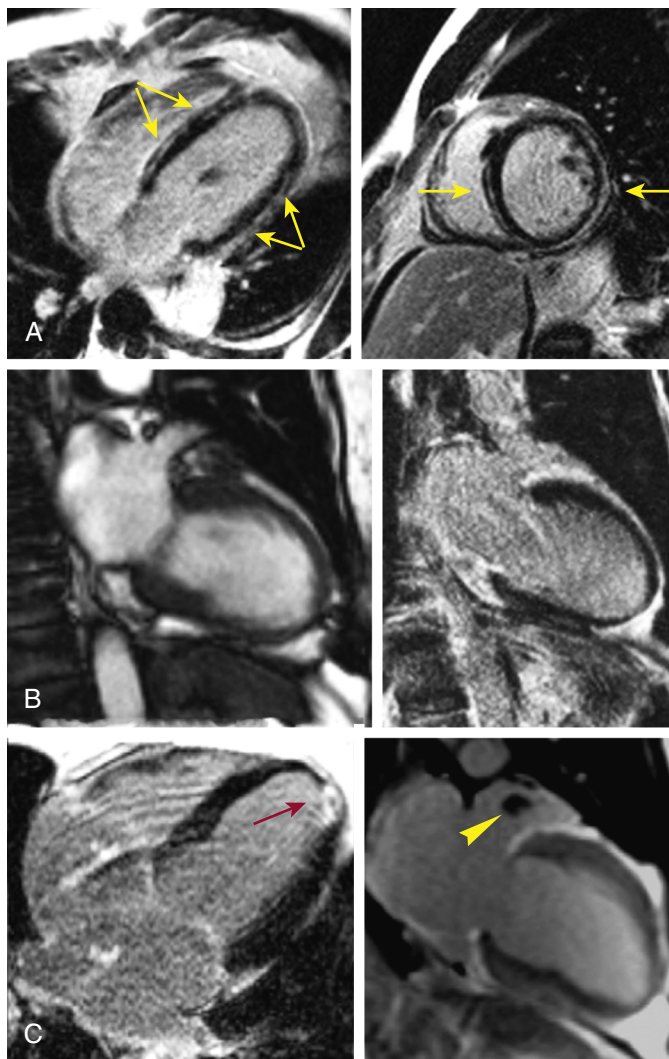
e12 Typical delayed-enhancement cardiac magnetic resonance images from three patients with chest discomfort, ST-segment elevation, positive troponins, and normal coronary arteries at angiography. (A) Linear, epicardial hyperenhancement (*yellow arrows*) is present and is indicative of myocarditis. (B) Cine and delayed enhancement images of a patient with sudden emotional stress and apical ballooning; the absence of hyperenhancement is consistent with Takotsubo cardiomyopathy. (C) Focal but transmural hyperenhancement (*red arrow*) involving the lateral apex is present and indicative of myocardial infarction because of temporary occlusion of a small diagonal branch off the distal left anterior descending coronary artery. Delayed-enhancement cardiac magnetic resonance image with a long inversion time (600 ms) shows a thrombus (*yellow arrowhead*) in the left atrial appendage, suggesting that an embolus led to the myocardial infarction. For an additional presentation of this image, [click here](#).
